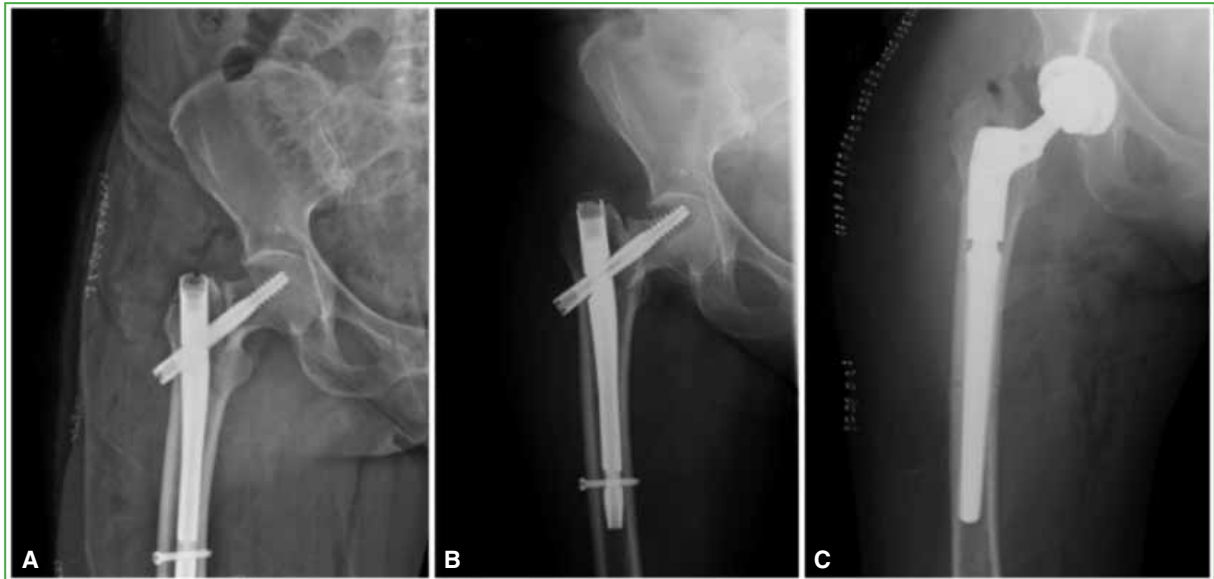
Anteroposterior hip radiographs of case number 10. A. Immediate postoperative period: a varus reduction is observed; the cephalic screw is in a superior position and has an increased tip-apex distance. B. Two months after surgery: cut-out implant failure is observed. C. After reintervention with total hip prosthesis.
